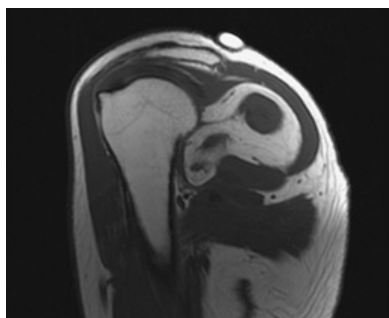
T1-weighted magnetic resonance imaging of the sagittal plane revealed a 6.08x3.84x4.07 cm mass lesion in the right shoulder with infraspinatus and deltoid muscle, and cystic changes with a rim-enhanced lipomatous tumor.
